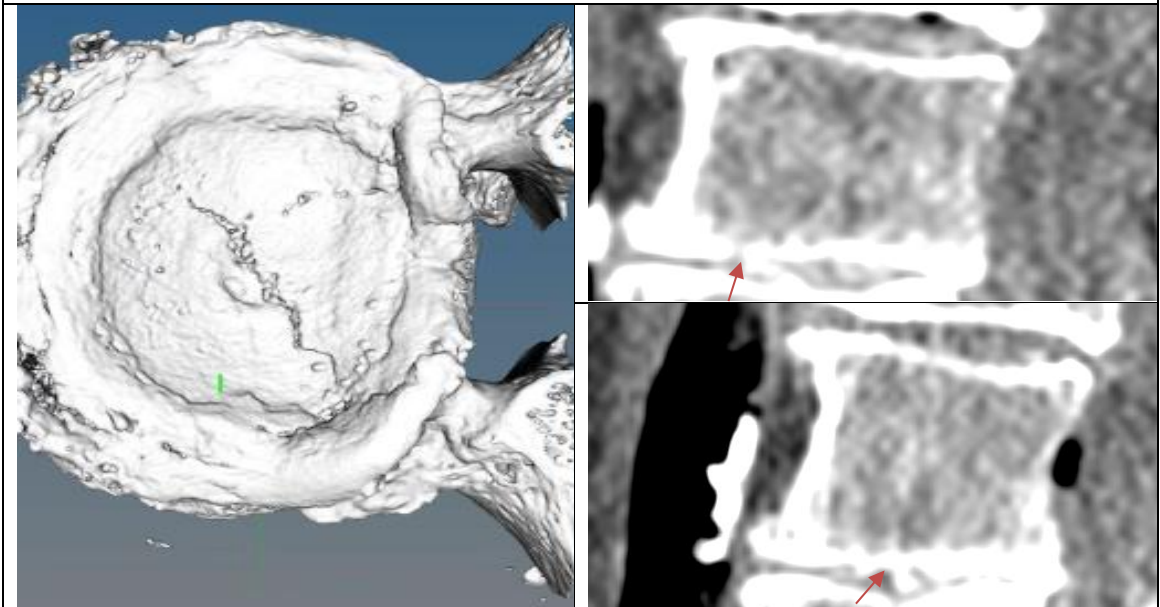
Sensitivity of endplate structural defect phenotypes assessments on Clinical CT (Brayda-Bruno and Feng) to the reference standard (μ CT)
